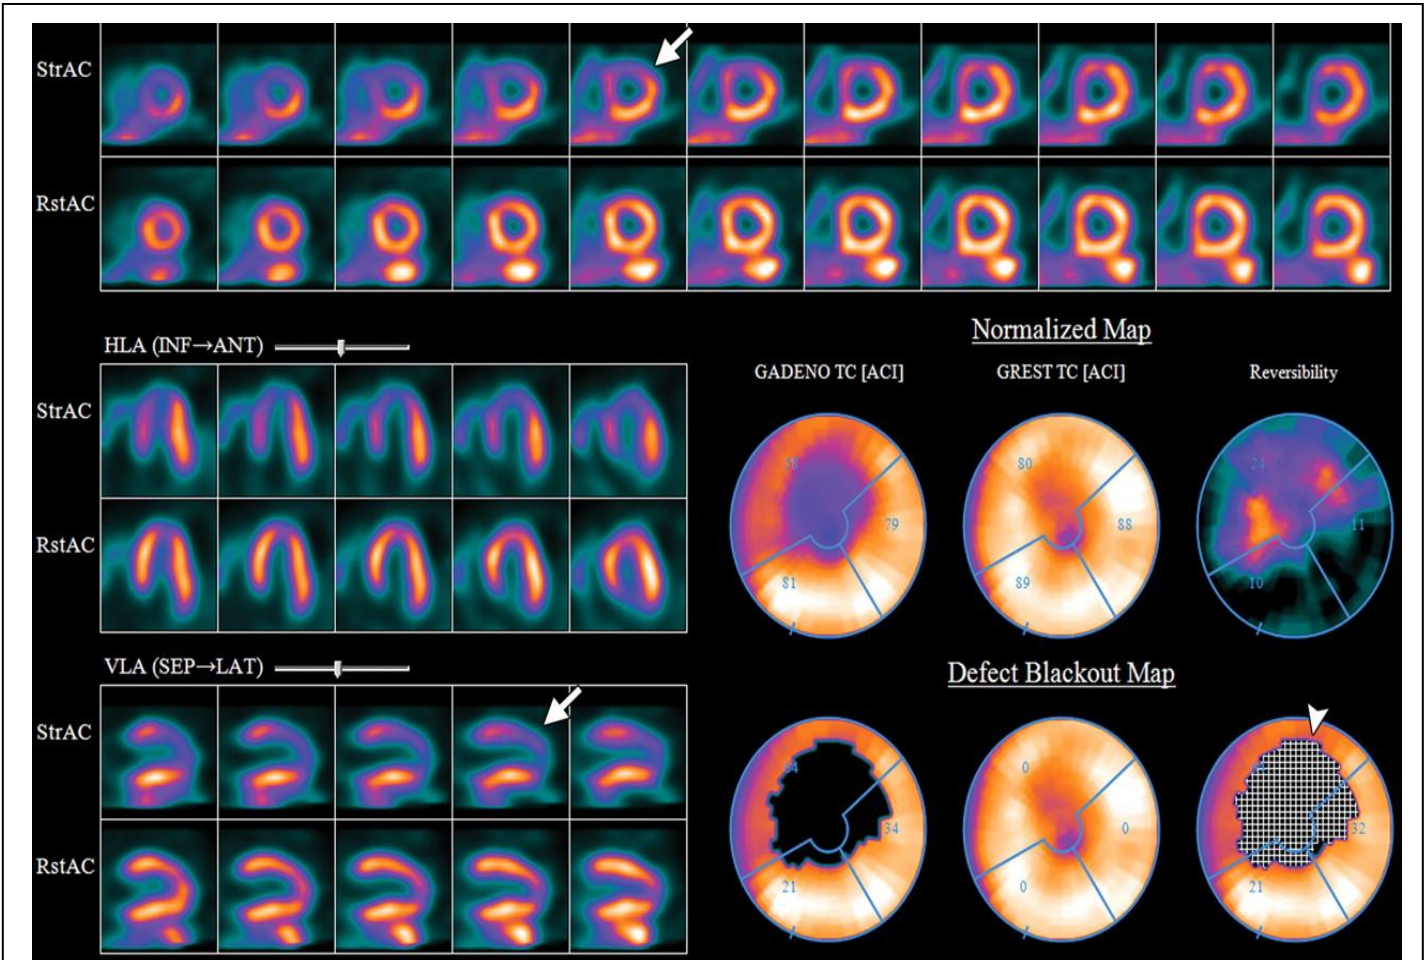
Myocardial perfusion imaging examination performed with SPECT/CT, stress and rest images [9]
